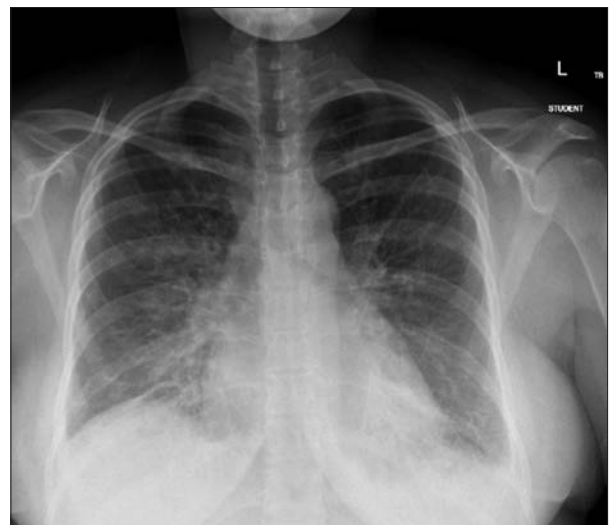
Plain chest radiograph, showing an enlarged heart size and increased interstitial markings.
